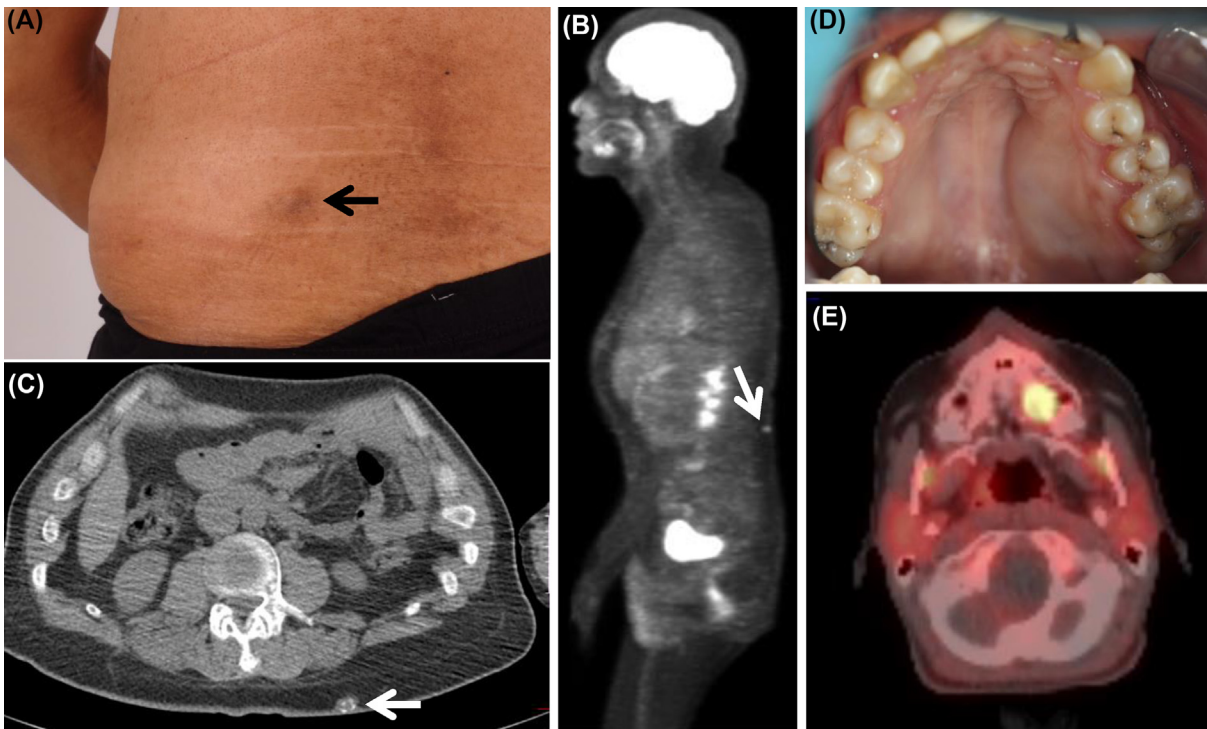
Tumors identified on physical examination. (A–C) The patient had a small, mobile, subcutaneous lesion on his back that he had noticed within the past several years (A, arrow). It showed marked metabolic activity on positron emission tomography/computed tomography (PET/CT) scan (B, arrow), and on CT windowing (C, arrow) it showed areas of calcification, which are often seen in phosphaturic mesenchymal tumors. (D and E) A 17-year-old girl was noted to have a mass in the roof of her mouth that she had noticed within the past several years (D). On merged ^{68}Ga -DOTA PET/CT scan (E) it was noted to have a high uptake of ^{68}Ga -DOTA, consistent with tumor-induced osteomalacia. In both cases, resection of the tumors led to complete remission.
